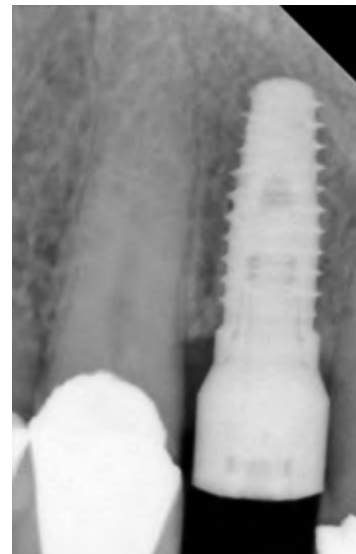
Periapical radiograph 10 weeks post implant placement. There appeared to be good bony adaptation around the entire circumference of the implant, without any radiolucencies. There was no pathology; the patient was ready to proceed with the definitive impression.
